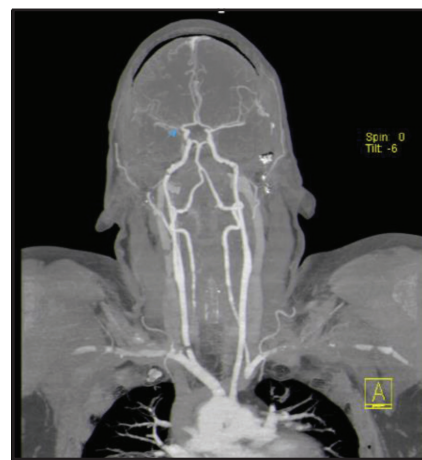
CT angiography showing loss of signals beyond proximal M1 segment of MCA.
